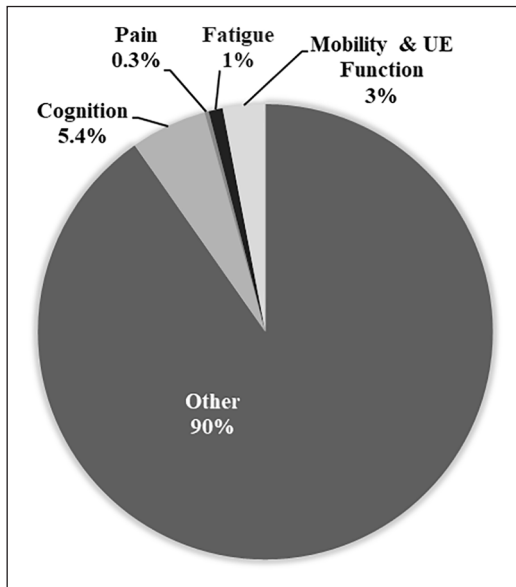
Percentage of total funds from the Progressive MS Alliance and member organizations spent on studies of the four highlighted symptoms. The section titled “Other” includes studies of the brain and spinal cord using imaging (MRI and PET), vision (including OCT and clinical measures), biomarker discovery and development.
